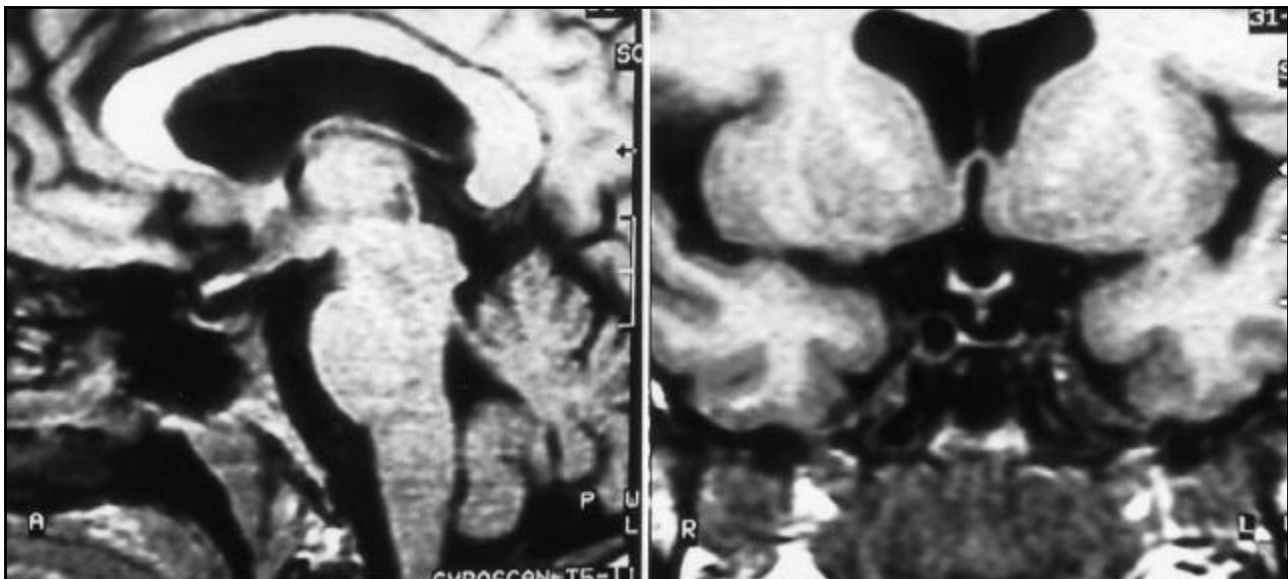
MRI T1-weighted midline sagittal section (A) and coronal section (B) 6 years after surgery showed a partially empty sella with a centrally located pituitary stalk, without evidence of tumor and/or collection.
